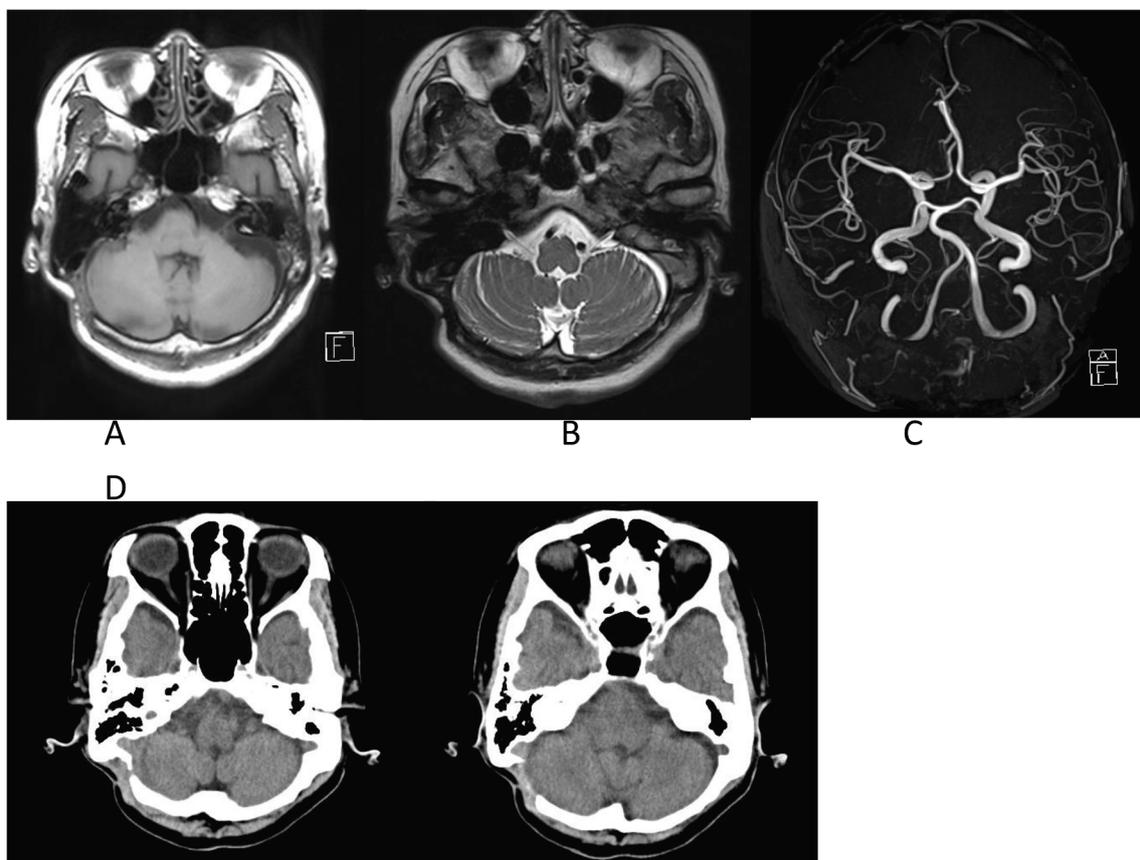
Brain MRI, T1 (A), T2 weighted image (B), brain MRA (C), Brain CT (D) of case 2.
